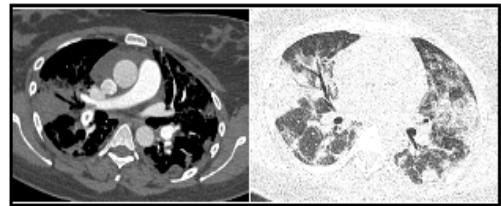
Axial CTPA image showing central inclusion defect/thrombus in right lower lobe pulmonary artery and axial HRCT image showing shows moderate to severe lung involvement evident by areas of ground glass attenuation and consolidation.
